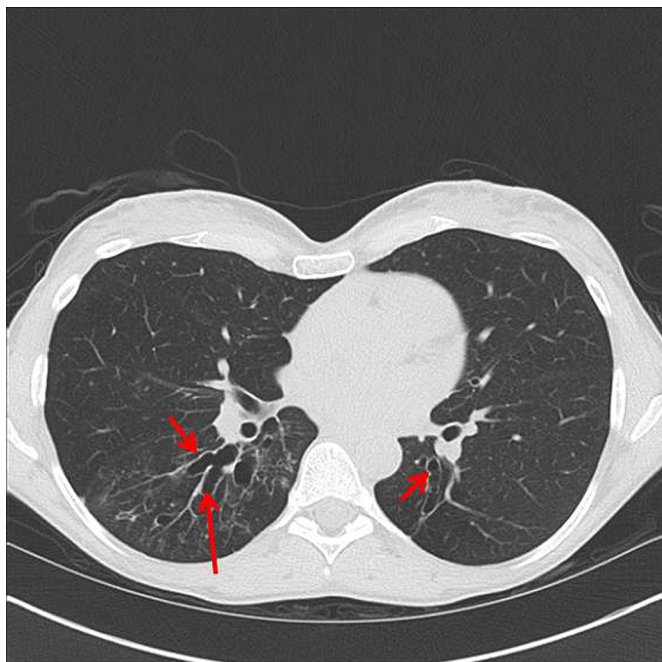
High-resolution computed tomographic examination of the lungs in a 50-year-old woman with long-standing allergic bronchopulmonary aspergillosis. The red arrows identify areas of bronchiectasis. The total IgE concentration was 304 kU/L, the anti-*Aspergillus fumigatus* IgE level was 3.49 kU/L (reference range, <2.0 kU/L), and the anti-*A fumigatus* IgG level was 4.98 kU/L (reference range, <2.0 kU/L).
